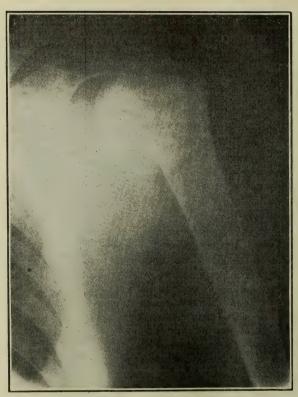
X-ray taken when patient first entered hospital, upon which the diagnosis of fracture at surgical neck of humerus was made. A closer inspection would have shown beginning malignancy. (Taken with screen image reversed.)
